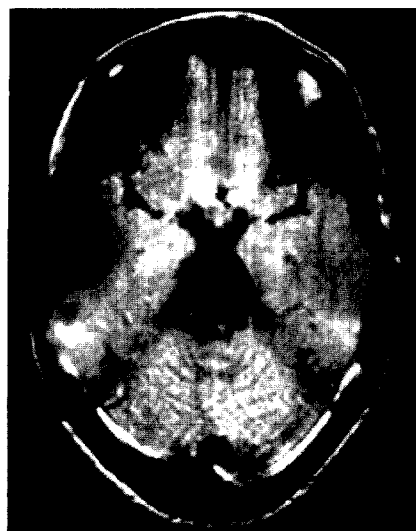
Magnetic resonance image in Case 4, an 18-year-old woman, 7 years after subtotal removal of pontine cavernous angioma. Signal changes occupy one-half of the pons, yet she remains neurologically normal and has not rebled clinically.
